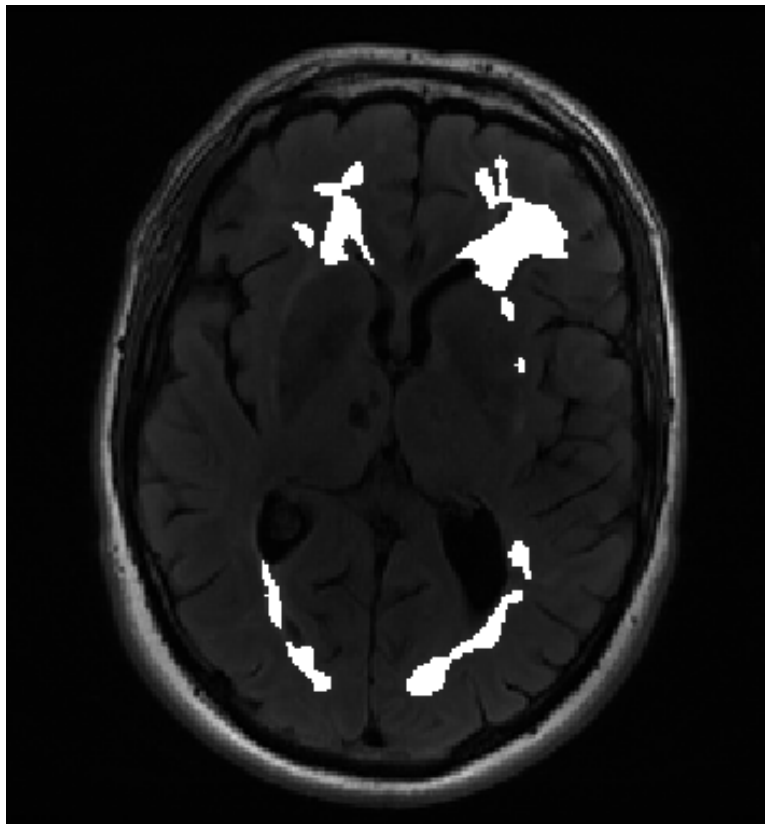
Example image of a T2-FLAIR scan marked for WMLs (white).
